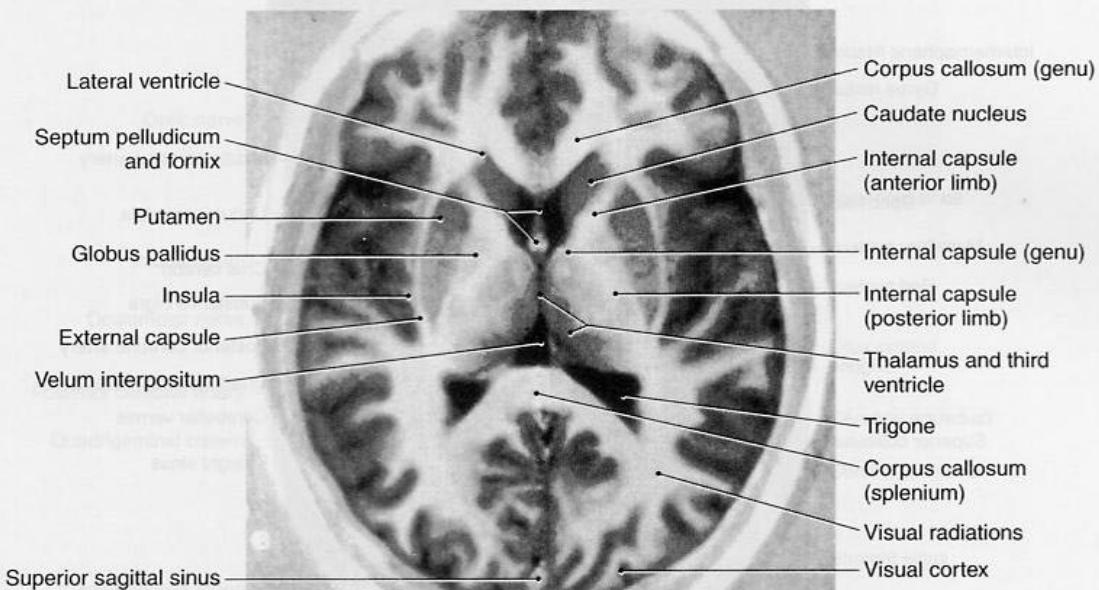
Axial magnetic resonance imaging section at the level of the internal capsule and basal ganglia. Note that the caudate nucleus bulges into the frontal horn of the lateral ventricle. In Huntington's disease, there is a massive loss of γ -aminobutyric acid (GABA)-ergic neurons in the caudate nucleus that results in hydrocephalus ex vacuo. A lesion of the genu of the internal capsule results in a contralateral weak lower face with sparing of the upper face. This is a T1-weighted image.
